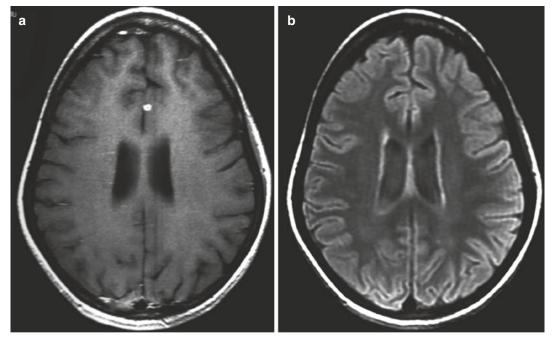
A 30-year-old female with TBM and tuberculoma. Her baseline MRI brain shows a left paramedian frontal small tuberculoma on axial post-contrast image (a) with minimal perifocal edema on FLAIR image (b). A
